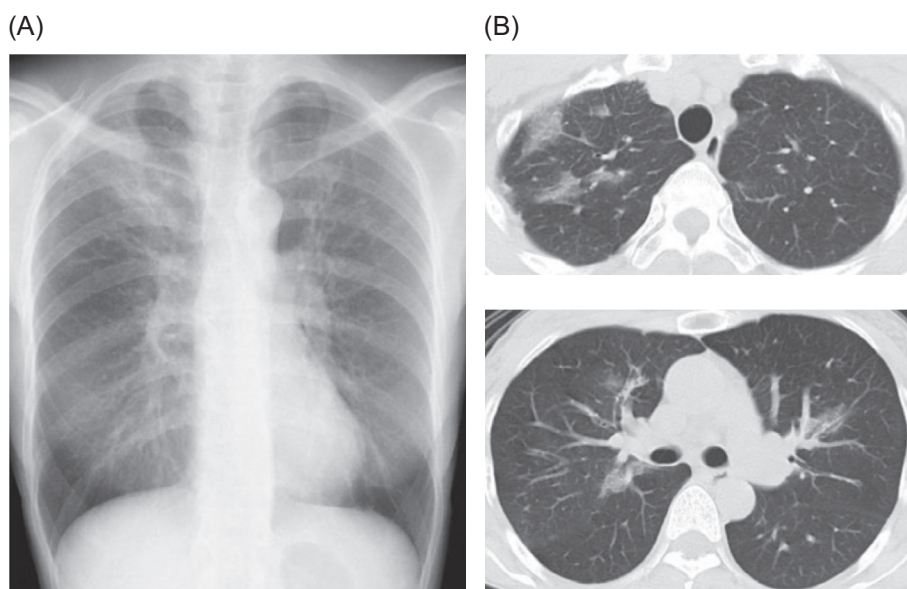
(A) Chest x-ray showing ground grass opacity in the right upper lobe. (B) Chest plain CT showing mild infiltration, ground grass opacities, and reticulo-nodular patterns in both of the upper lobes, indicating interstitial pneumonia.
